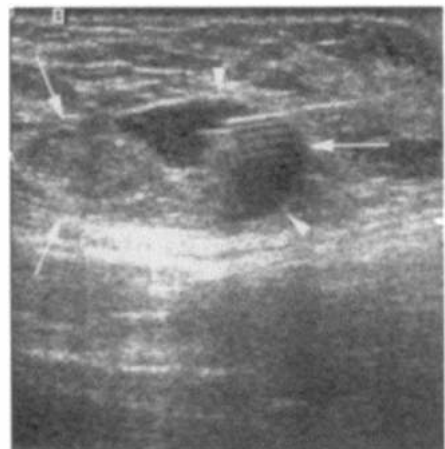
• Ultrasound-guided FNA biopsy of axillary lymph node metastases.
